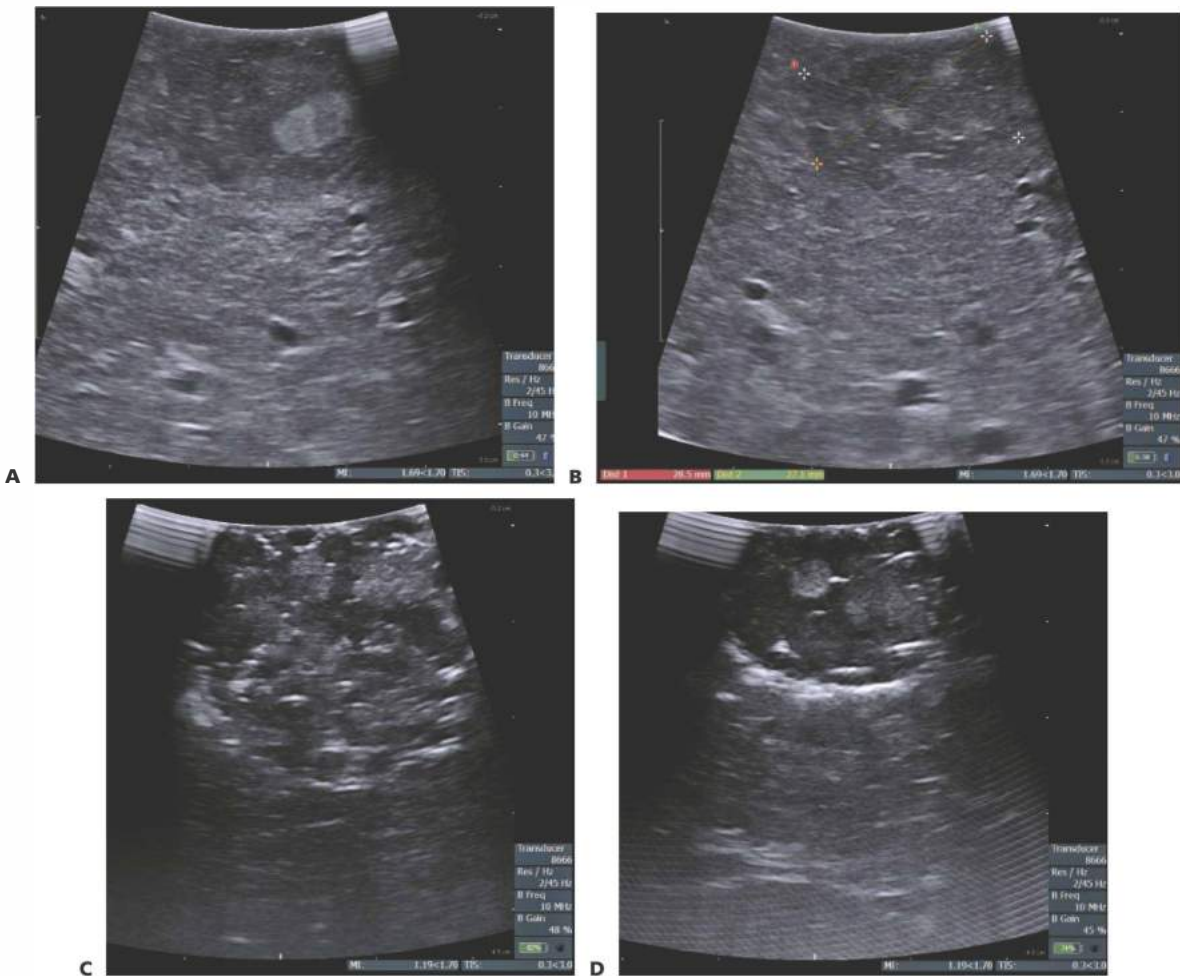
• Laparoscopic ultrasound (US)-guided RFA of a peripheral HCC. A. Before ablation. B. Lesion measurements. C. During ablation. D. Immediate postablation. Note the typical artifacts created by the gas formed by tissue boiling.
